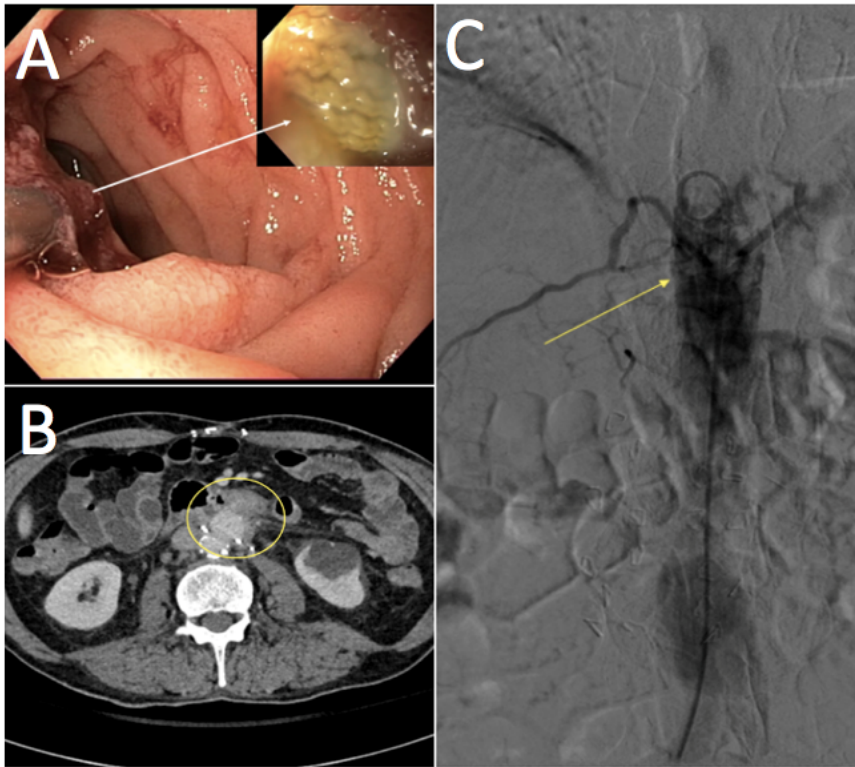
A. Upper endoscopy showing erosion of the duodenum with a visible vascular prosthesis. B. Contrast enhanced CT: heterogeneous morphology with posterior wall thickening is shown in the third part of duodenum that is associated with a small amount of free fluid. No intra-abdominal free air was observed. C. Arteriography: an endoluminal aortic prosthesis is shown with no leak of contrast or any signs of an aortoduodenal fistula.
